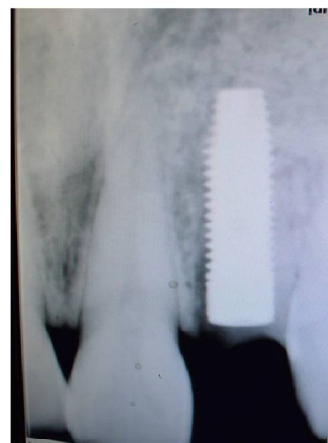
Radiograph showing the implant
